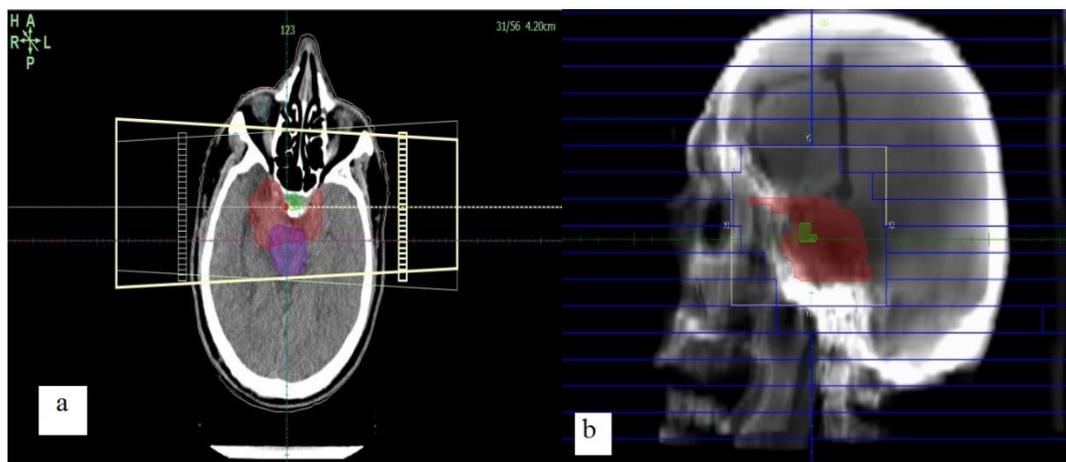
A sample treatment plan for a brain tumor, (a) the axial view and the tumor was depicted in red color, purple for brain stem, and pituitary gland in green. (b) A digitally reconstructed radiograph of the same brain tumor plus multi-leaf collimators depicted with blue color.
